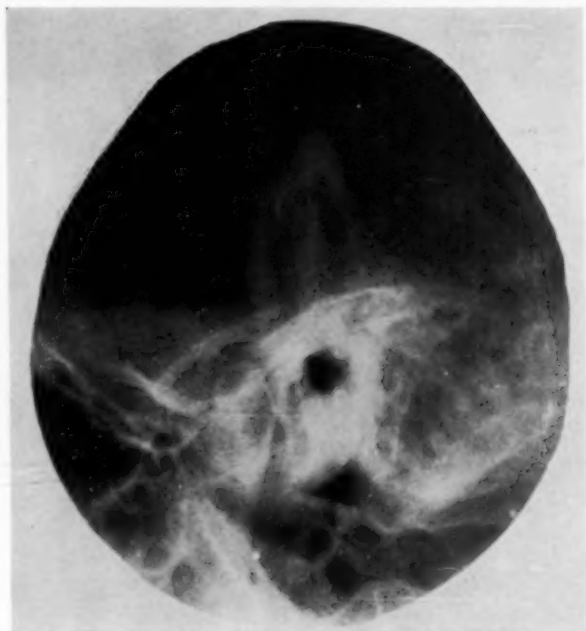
X-ray of extensive mastoiditis in previously pneumatized cavity with extensive sclerosis beginning.
